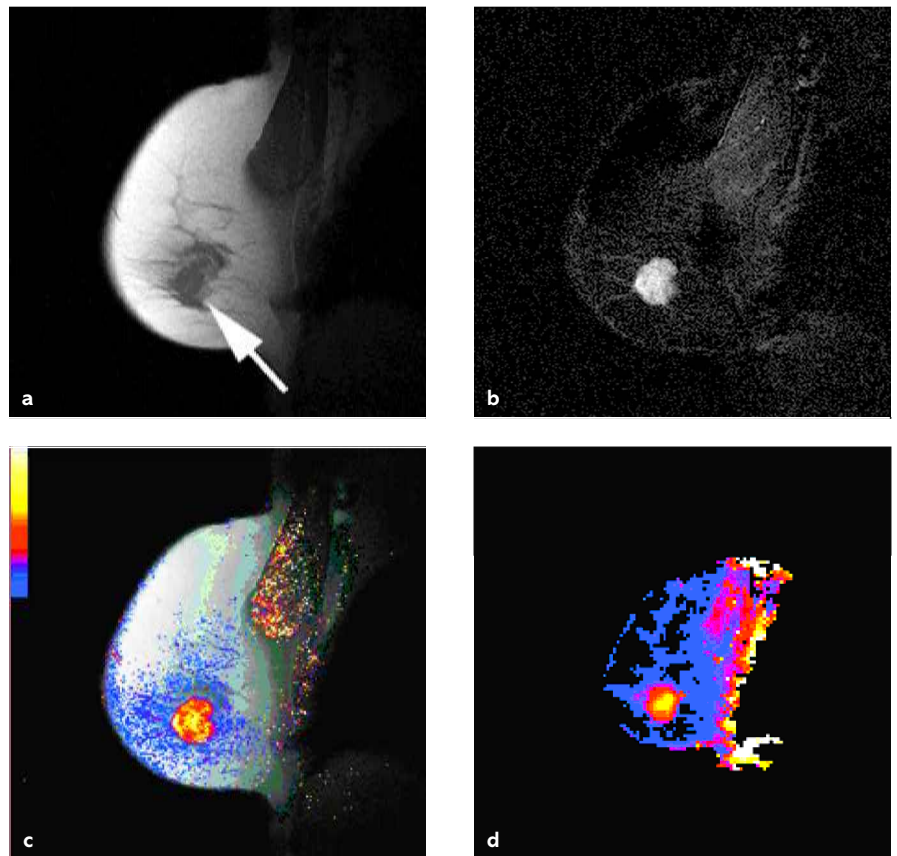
Dynamic contrast-enhanced magnetic resonance imaging of invasive ductal breast cancer: (a) sagittal anatomical image of the breast shows a mass in the lower part of the breast (arrow); (b) subtraction image after administration of contrast medium shows an enhancing mass. No other enhancement is visible; (c) and (d) corresponding images mapping permeability surface area product and relative blood volume at the same anatomic position within the mass, fat and muscles. The blood volume image is at lesser resolution.
